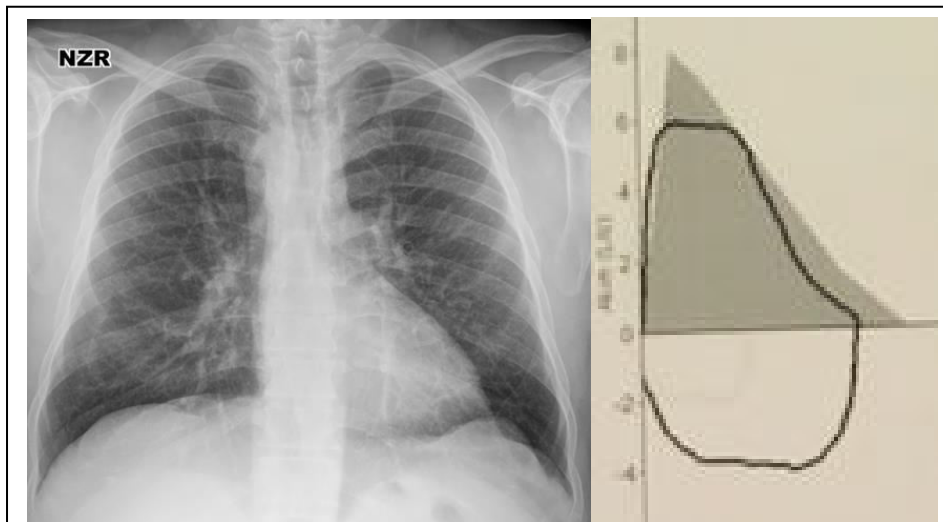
Chest radiography of 54 years-old male showing the right sided arcus aorta and flow-volume curves showing the quadrilateralization pattern on spirometry.
